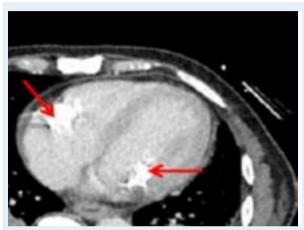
Cardiac CT: important annular calcifications
